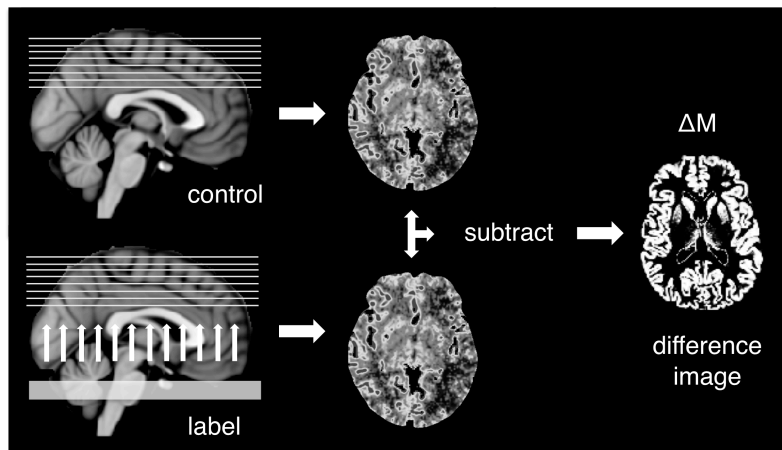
Basic concept of ASL perfusion MRI. Taking the difference of the control and label images yields an image ($\Delta M = M_{\text{control}} - M_{\text{label}}$) that is proportional to CBF.
